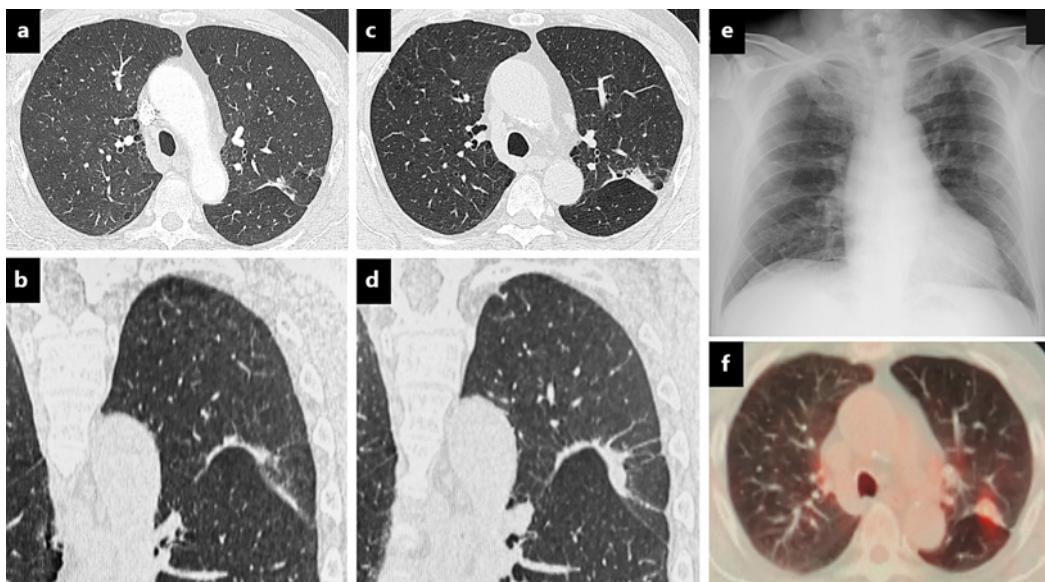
Chest radiological images of the patient with lung adenocarcinoma. A band-like lesion extends along the left major pleural fissure in the horizontal view (a) and in the frontal view (b). Two and a half years after the initial presentation, the lesion is enlarged as shown in the horizontal view (c) and frontal view (d). e This lesion remains invisible on conventional chest radiography. f The lesion shows the accumulation of ^{18}F -fluorodeoxyglucose on positron emission tomography.
